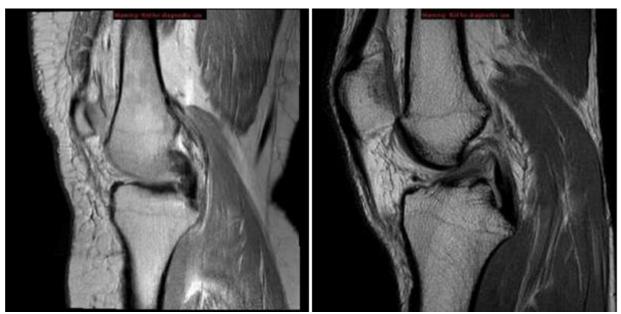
MRI Showing Partial ACL Tear
